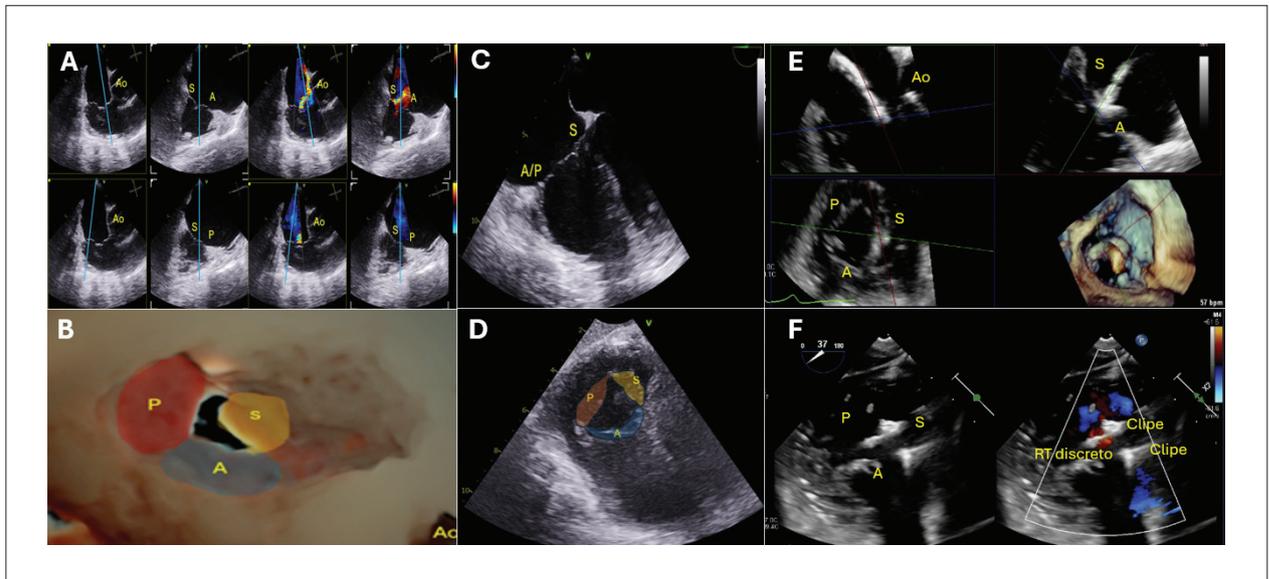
Transesophageal echocardiographic windows before and during the TEER procedure. (A) RV inflow/outflow tract windows. (B) 3D image of the TV demonstrating significant coaptation failure. (C) Four-chamber view. (D) Transgastric view. (E) Flexi-slice or multiplanar reconstruction of the TV. (F) Transgastric window with the biplanar or X-plane tool after implantation of two clips in the anteroseptal commissure with mild TR. A: anterior leaflet; S: septal leaflet; P: posterior leaflet; Ao: aorta; TR: tricuspid regurgitation. Images E and F were provided by Julien Ternacle, Bordeaux, France
